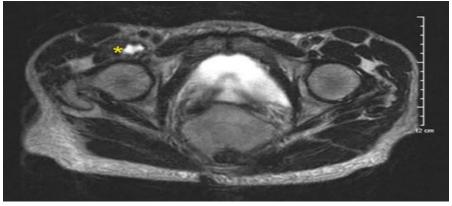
Coronal T1 Weighted MRI of Hip demonstrating rupture of distal portion of the iliopsoas muscle with surrounding hemorrhage and tissue edema.
